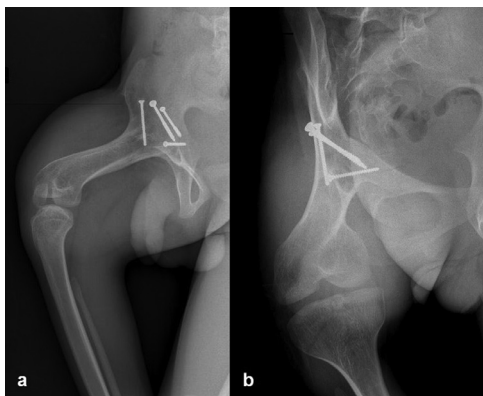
Anteroposterior (a) and lateral-oblique (b) right hip radiographs clearly demonstrate the hip fusion, the positions of the screws and severe femoral shortening. The right fibula is also shortened (b).
